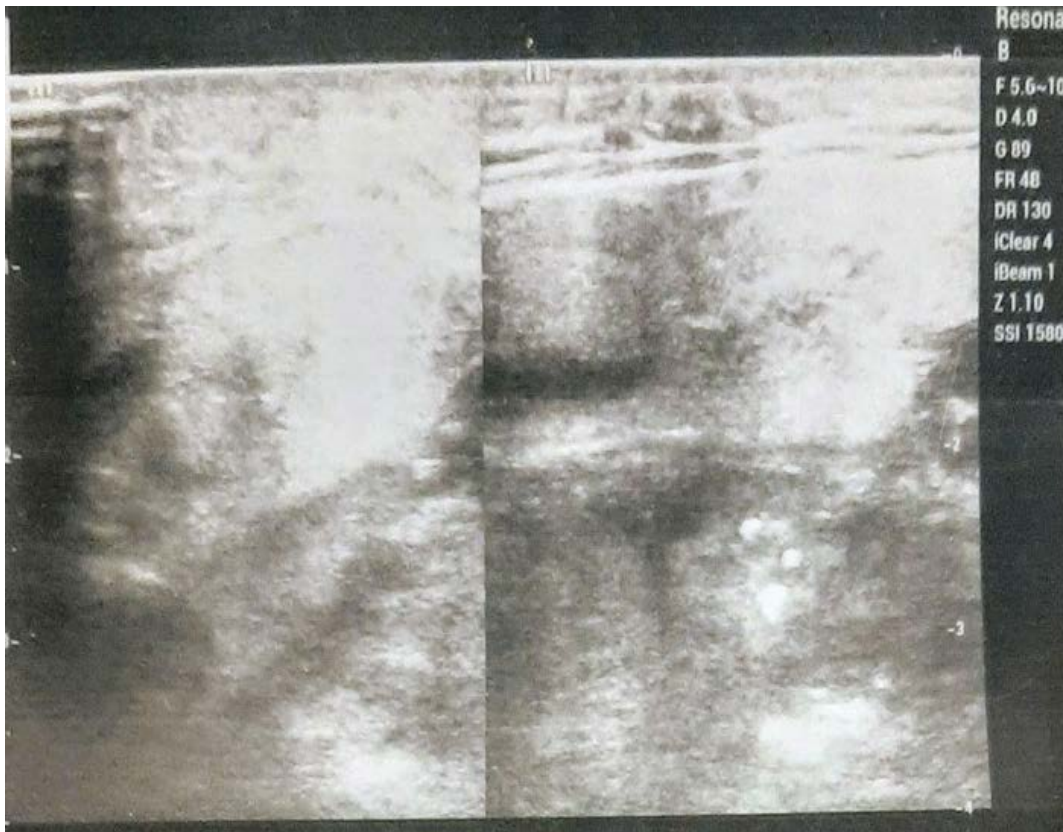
Ultrasound finding of enlarged and necrotic lymph nodes in the left submandibular region.
